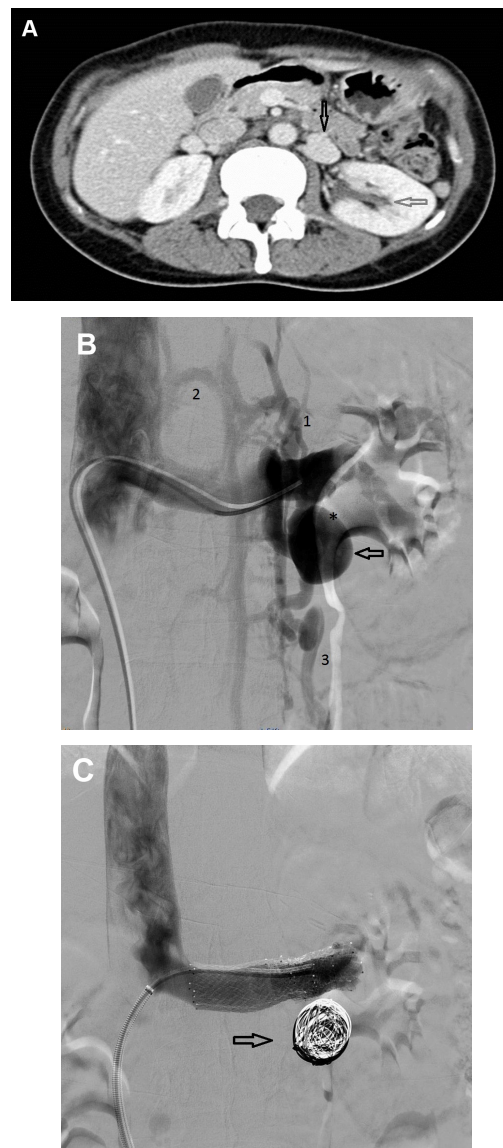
In A, contrast-enhanced computed tomography (CT) of the abdomen reveals a vascular aneurysm (black arrow), which compresses on the left pelvi-ureteric junction (PUJ), causing mild left hydronephrosis (grey arrow). In B, renal venogram shows a venous aneurysm (black arrow) arising from the distal left renal vein (LRV), causing compression on the left PUJ. Backflow into the hemiazygous system (1), left paravertebral venous plexus (2) and left gonadal vein (3) are noted, objective evidence of increased venous pressure (IVC). The pressure gradient between the LRV and IVC measured approximately 5 mmHg. In C, post-treatment venogram shows complete occlusion of the venous aneurysm (black arrow). In addition, satisfactory flow across the stented LRV is seen. Of note is also the absence of backflow into the LRV venous tributaries, indicative of reduced left renal venous pressure.
